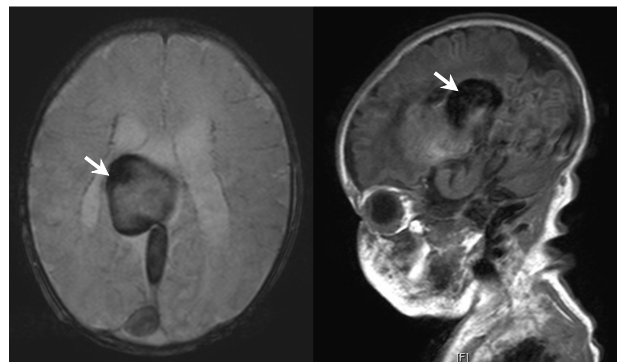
Postnatal brain MRI of a vein of Galen aneurysmal malformation (right) combined with a secondary ventriculomegaly and showing low signals on the margin of ventricle, strongly suspicious for intraventricular hemorrhage (left).
